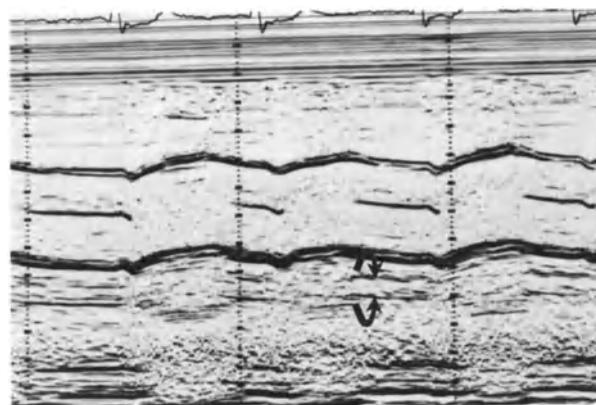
M-Mode echocardiogram from a patient with mitral stenosis and thrombus producing mobile echoes (curved arrows) in the left atrium.
